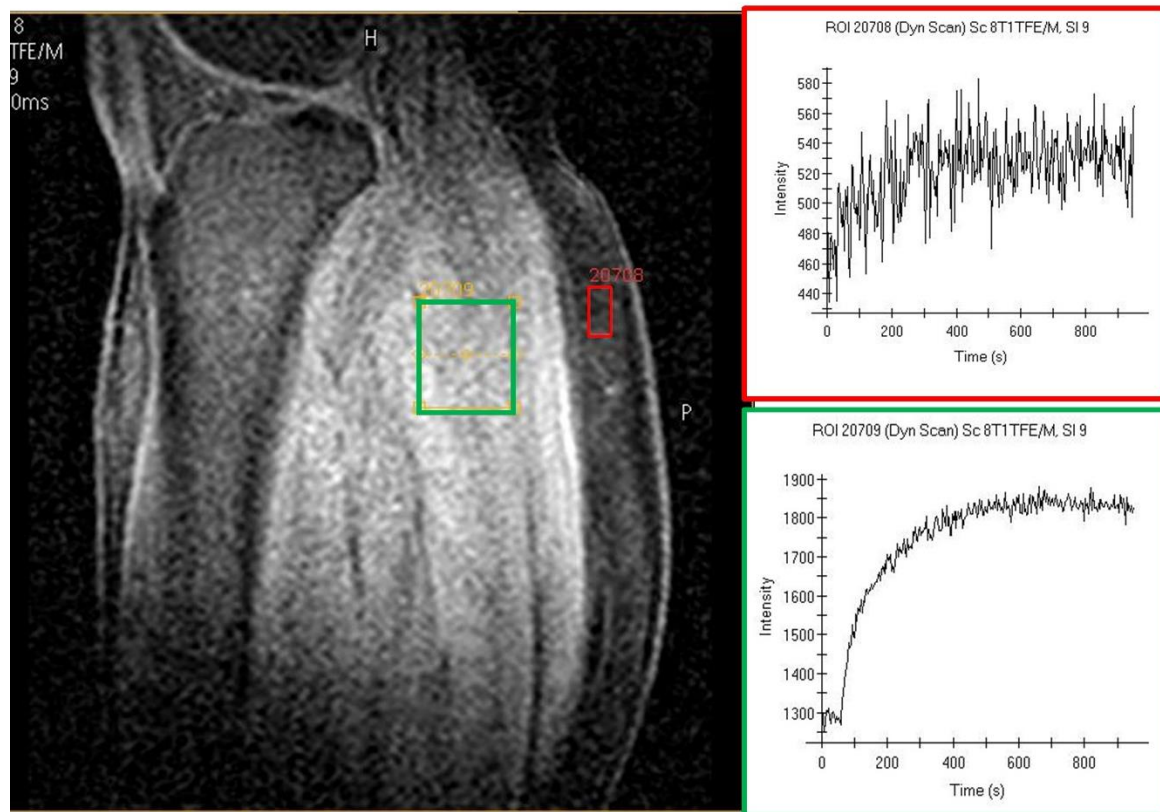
DCE-MRI enhancement curves for adipose tissue (red) and calf muscle (green) demonstrates the relatively minimal Gadolinium enhancement of adipose tissue.
